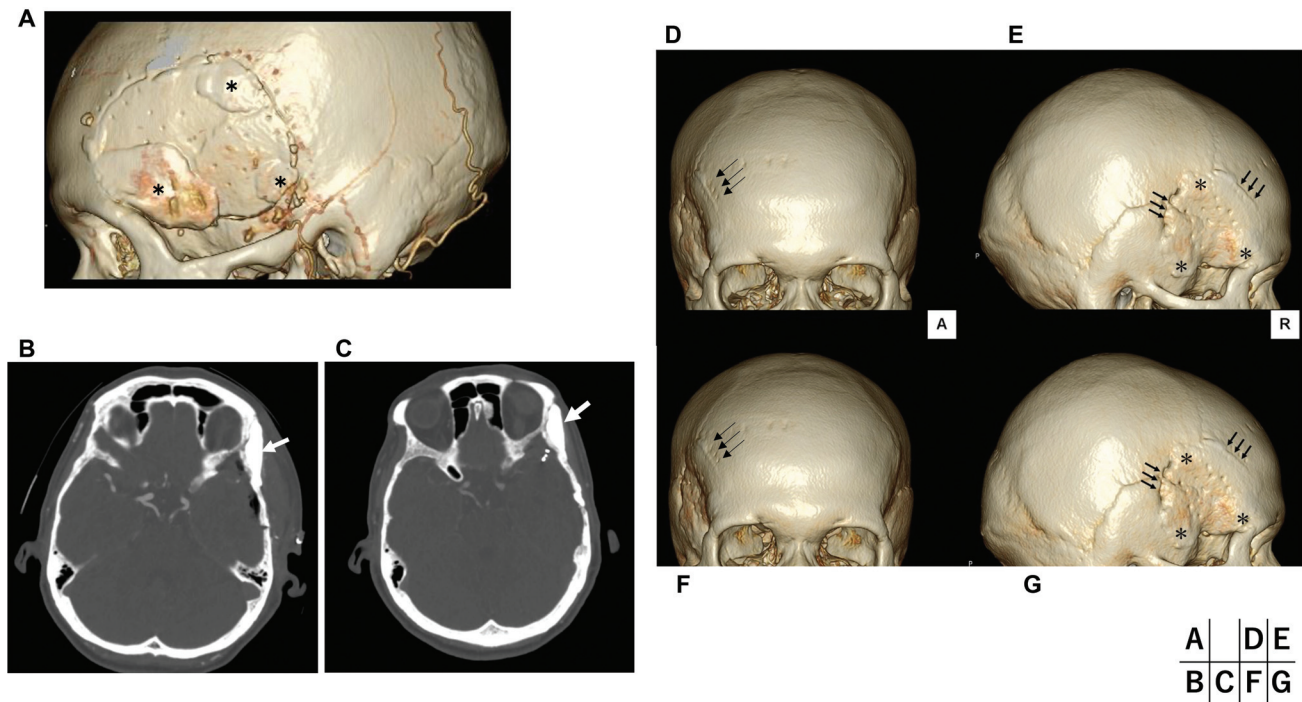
Outcome of the craniotomy using a diamond-coated thread wire saw. The seventh postoperative day. (A) Lateral view of three-dimensional computed tomography (3D-CT) scan of a patient who underwent left frontotemporal craniotomy using a diamond T-saw and reconstruction using calcium phosphate cement (asterisks) without metal fixation. The seventh postoperative day. (B) axial bone image of CT scan. Anteroposterior 3D-CT scans on the first postoperative year. (C) axial bone image of CT scan. Anteroposterior 3D-CT scans on the third postoperative year. (D) The bone flap was fixed by sutures passing through the opposed small drill holes beside the narrow cutting line made by a diamond T-saw (black arrows). Lateral 3D-CT scans on the first postoperative year. (E) A patient who underwent right frontotemporal craniotomy using a diamond T-saw and reconstruction with calcium phosphate cement applied to the burr hole and the temporal base bone defect (asterisks). The cosmetically good reconstruction of the temporal base bone defect using calcium phosphate cement (asterisks). Anteroposterior 3D-CT scans on third postoperative year. (F) Lateral 3D-CT scans on the third postoperative year. (G) The calcium phosphate could completely cover the burr hole and the temporal base bone defect (asterisks). Satisfactory beauty long-term fixation of the bone flap without metal fixation could be obtained.
